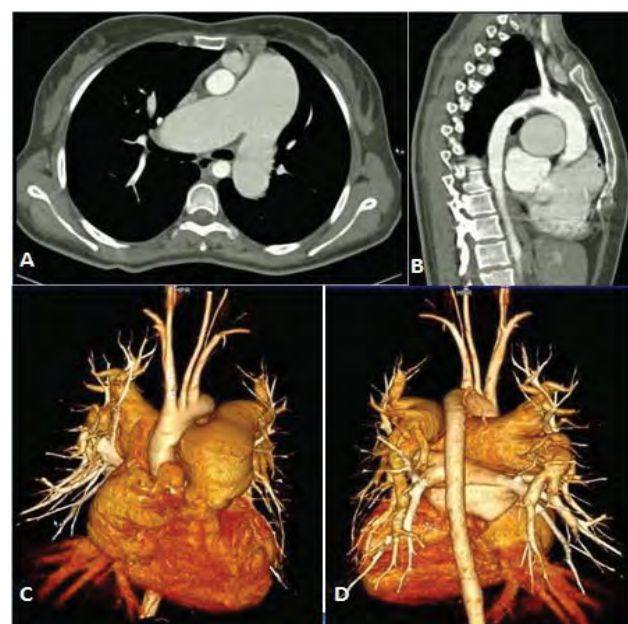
Angiographic CT demonstrated a dilated pulmonary artery and right cavities in axial section (A), sagittal section (B) and 3D reconstruction (C and D).
